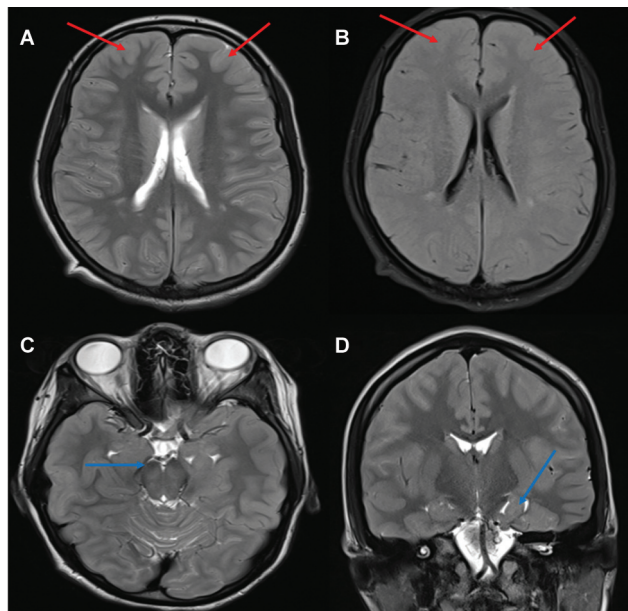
Magnetic resonance imaging (MRI) of the brain. (A) Axial T2-weighted (T2W) image shows diffuse cortical edema in bilateral frontal lobes (red arrows). (B) Axial fluid attenuated inversion recovery (FLAIR) image shows hyperintense signal in the involved cortex with loss of gray-white differentiation (red arrows). (C) Axial T2W image shows effacement of the basal cisterns (blue arrow). (D) Coronal T2W image shows left-sided uncus herniation (blue arrow).
